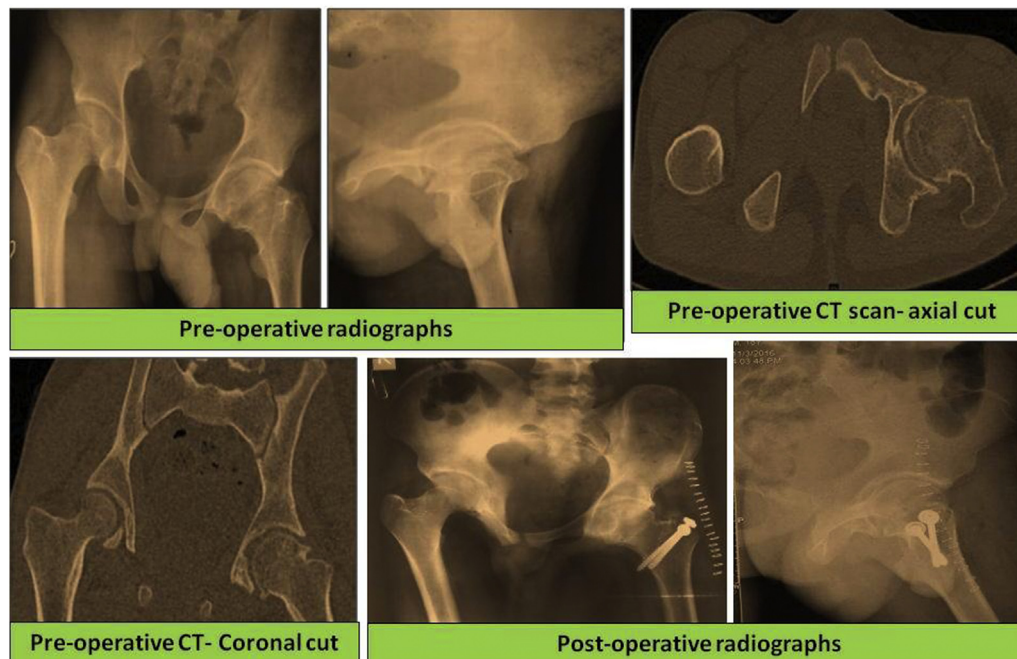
Pre-operative plain radiographs, pre-operative CT sections and post-operative radiographs.
